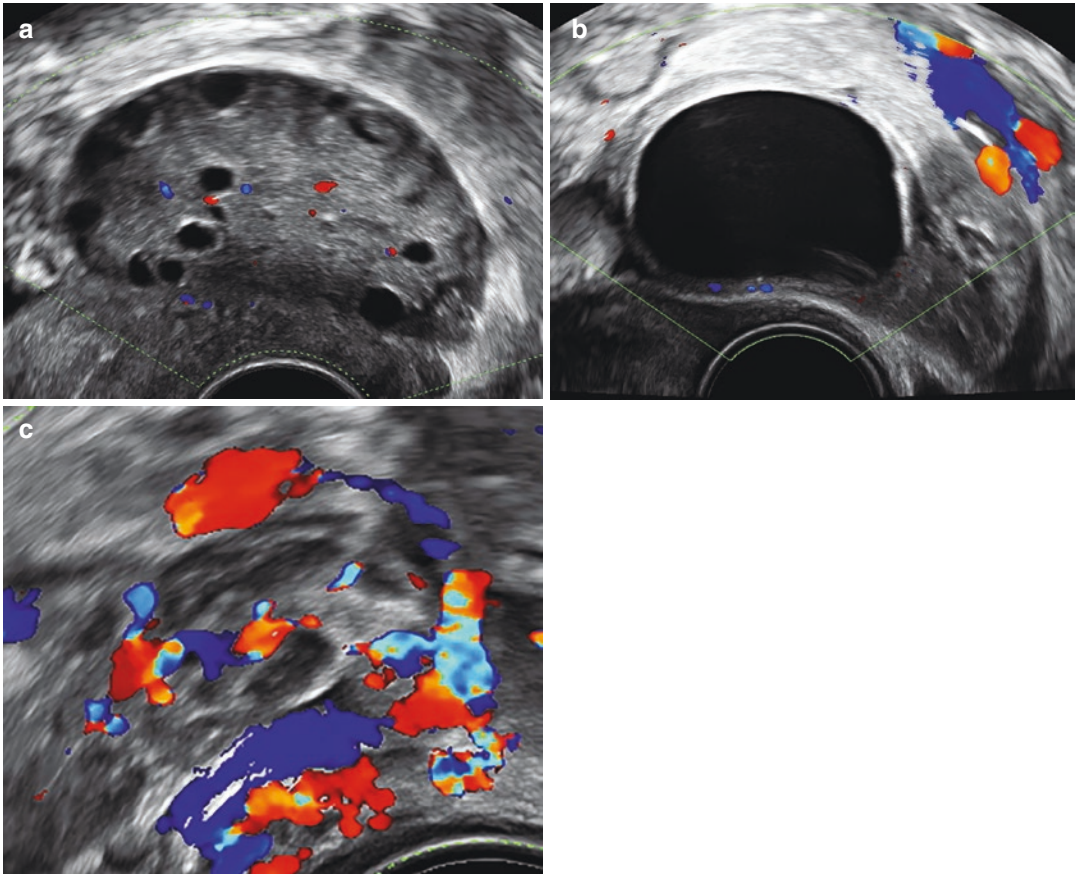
Ultrasound findings in ovarian torsion. (a) String of pearls demonstrated by the presence of small cysts mostly at the periphery of the ovary. (b) Ovarian
